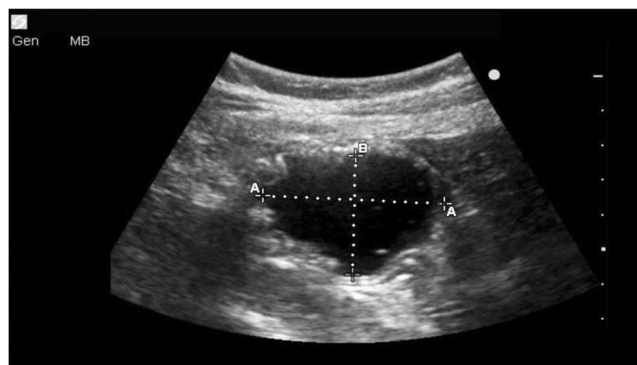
Gastric ultrasound view. *legend* Measurement of cross-sectional area to assess gastric antral contents
